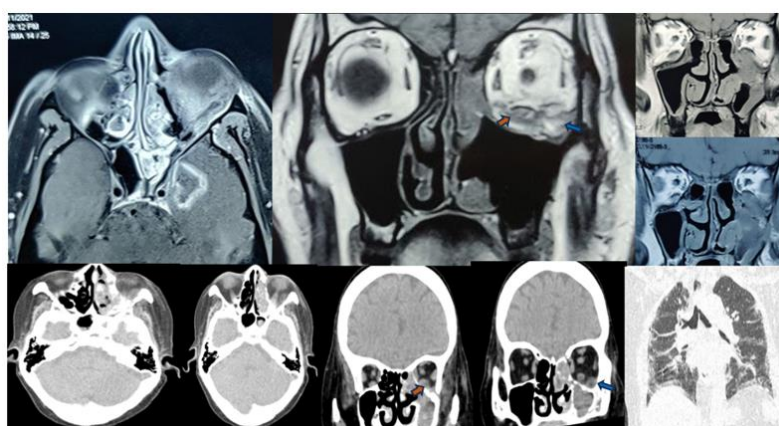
There is hypodense collection (blue arrows) along inferior wall of left orbit in extraconal compartment with bulky inferior oblique muscle (orange arrows) with adjacent fat stranding. HRCT chest showing GGOs and fibrotic opacities S/O post COVID-19 sequelae.
